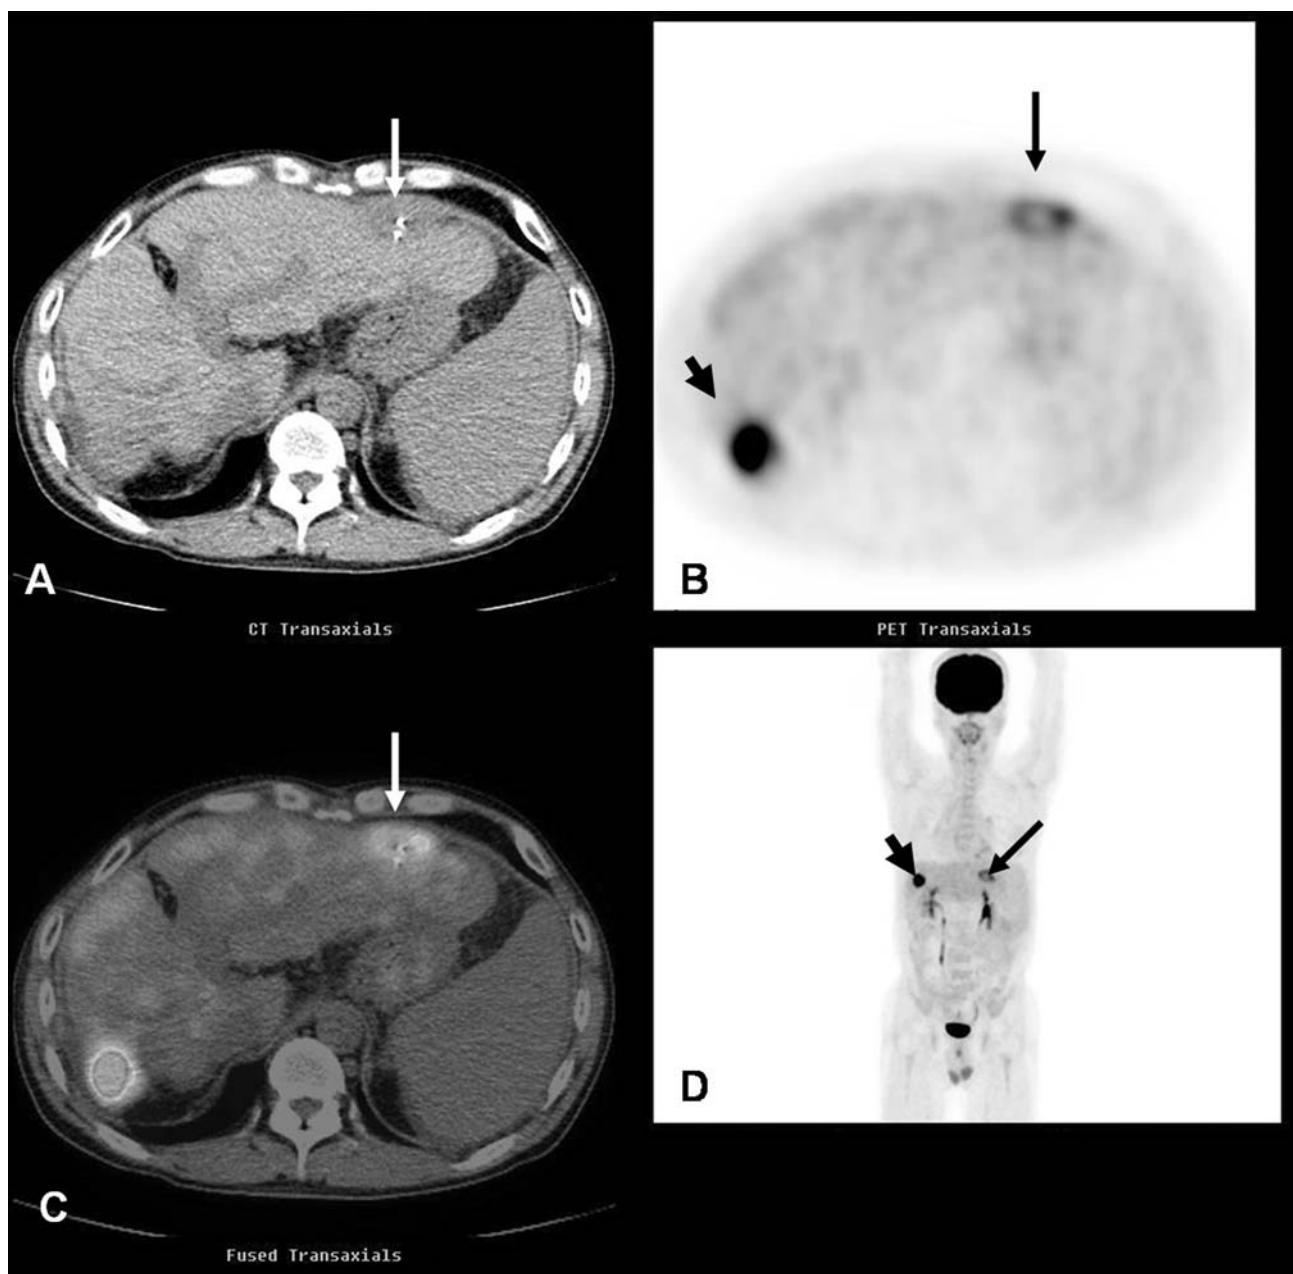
A 45-year-old hepatitis B virus carrier was found to have liver cirrhosis and HCC 6 years previously. He had undergone hepatectomies and was followed with serum AFP, US and CT for 6 months. The serum AFP level progressively elevated and was higher than 5000 ng/mL, but US and CT imaging was normal. Therefore, the patient underwent FDG-PET/CT study using a GE discovery LS PET/CT hybrid imaging scanner. The short arrow points to an intense FDG uptake in the right lobe of the liver in the transaxial (B) and projection (D) image. The long arrow points to a halo of increased FDG uptake in the left lobe of the liver with the surgical clip (A, B, C). In addition, a combination of the anatomical (A) and physiological (B and D) images shows the right lobe of the liver is shrunken with splenomegaly due to cirrhosis of liver. The patient then underwent TAE therapy.
